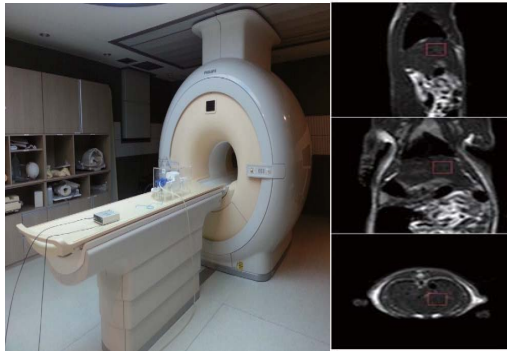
3T Human MRI (Philips Achieva TX System) and MR imaging showing volume of interest.
